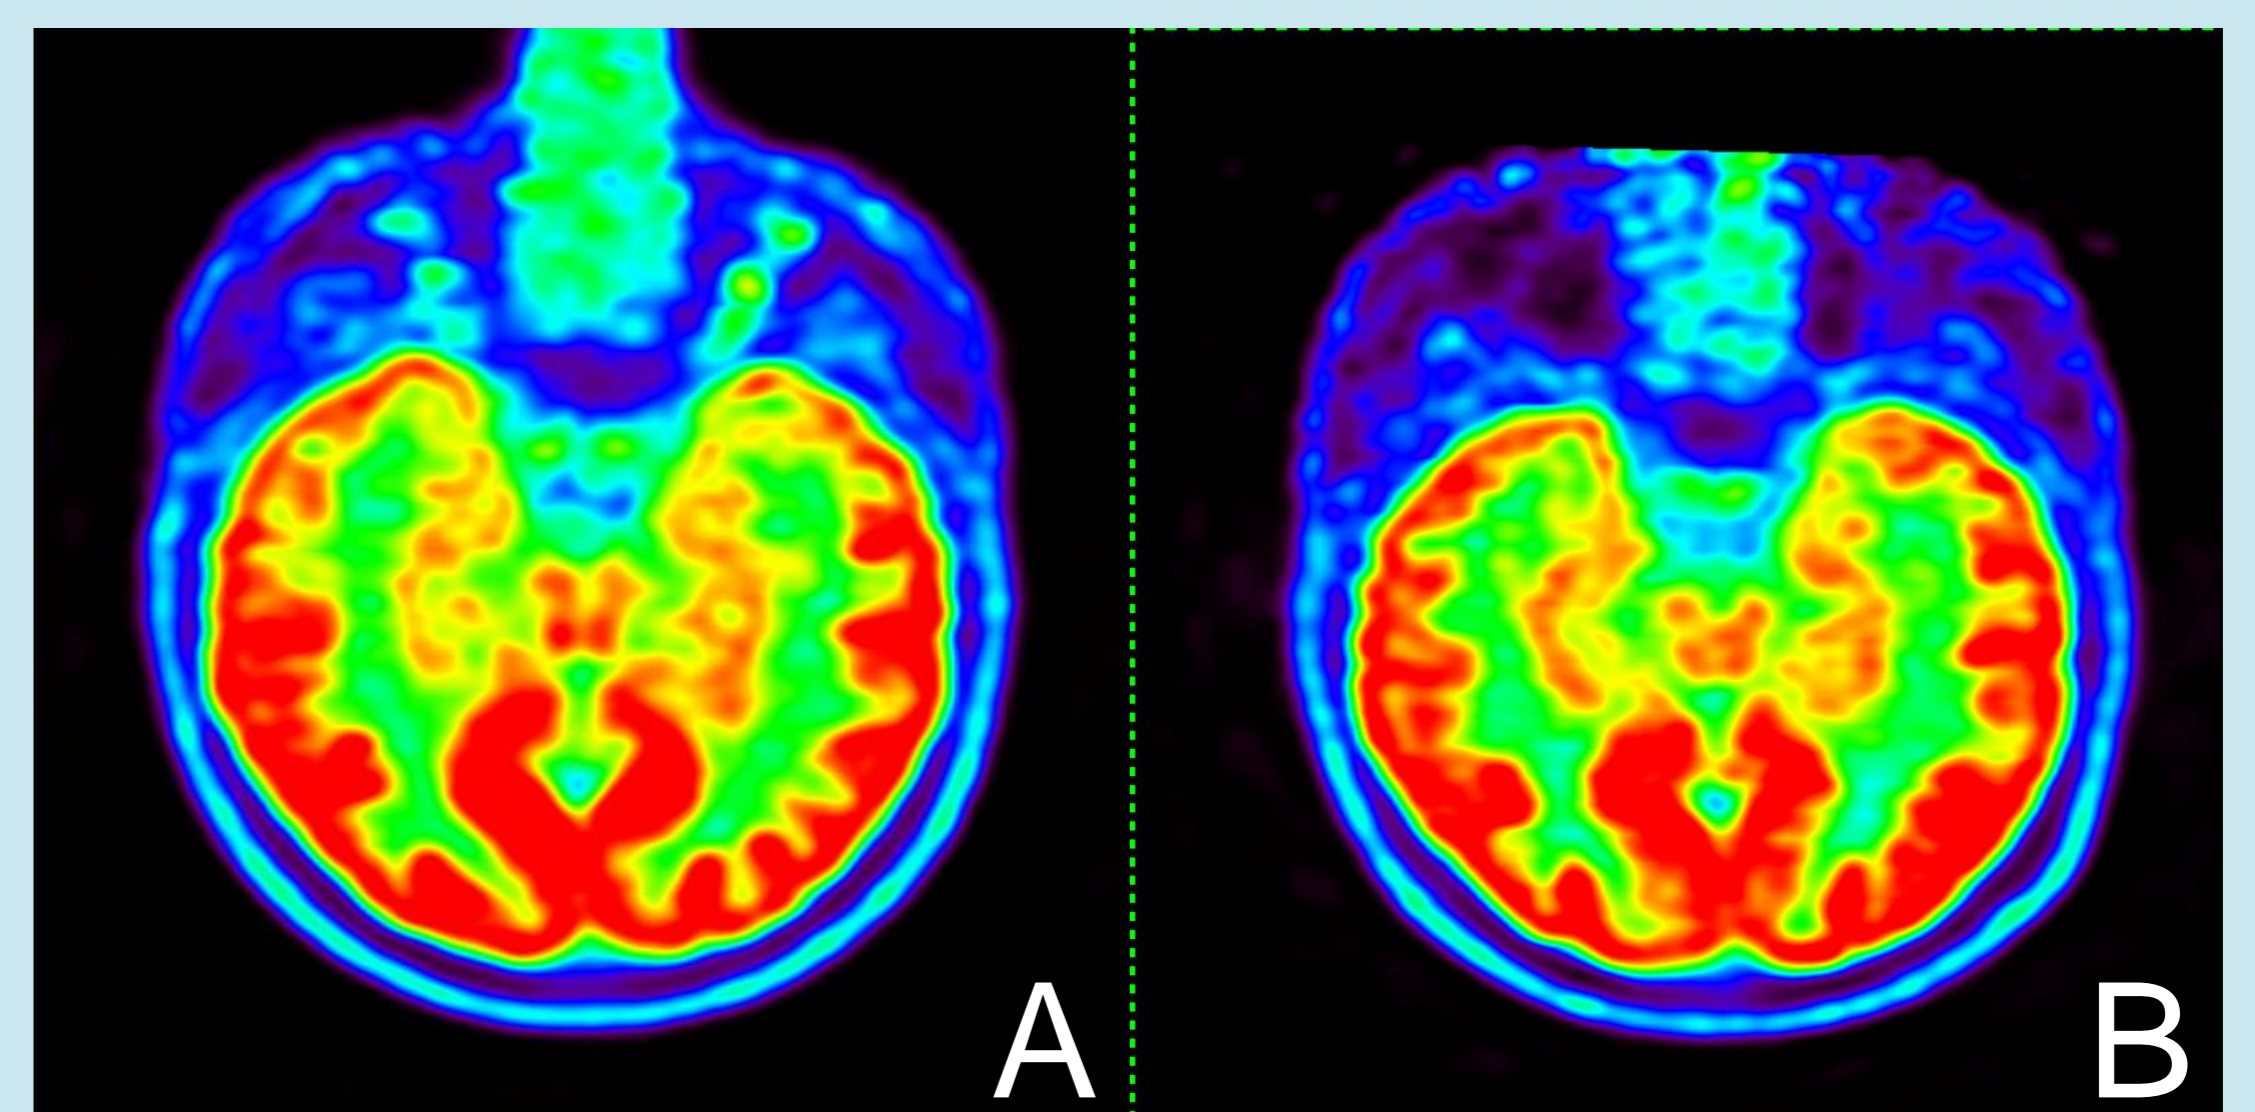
18 F-FDG PET Brain: baseline (A) and after 1-year of follow-up (B)
